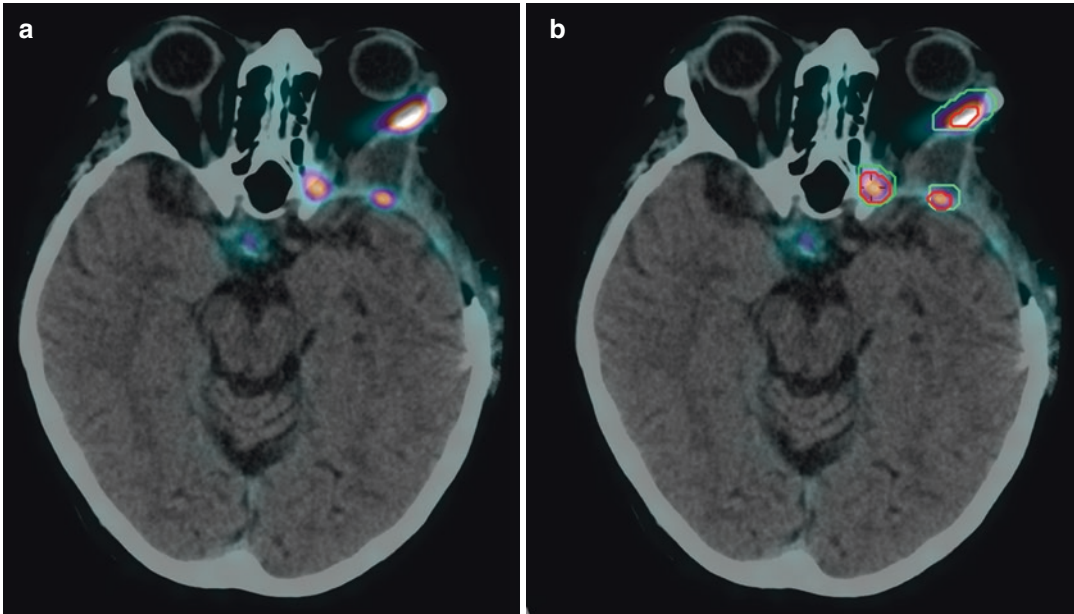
(a) PET-CT with Ga-68 Dotatate in a patient after non radical excision of a large left frontal meningioma. Residual tumor areas are clearly visible, with intense radiopharmaceutical uptake. (b) The same image after
